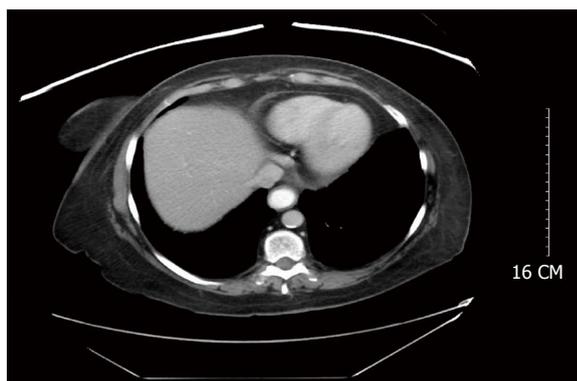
Computed tomography scan of the abdomen and pelvis with contrast showing enteric contrast within the dilated distal esophagus, and was suspicious for mild stricture at the gastroesophageal junction.
